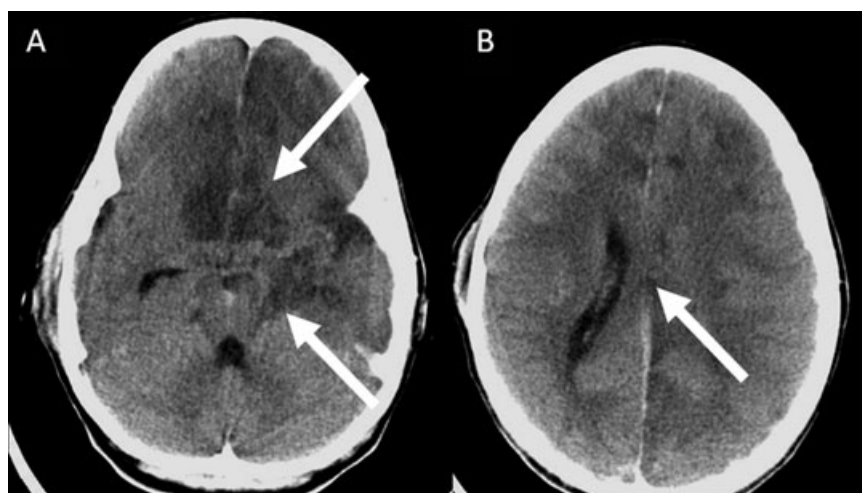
Axial CT images (A, B) show the complications of subfalcine and descending transtentorial herniation because of a left sided convexity SDH. The midline is pushed to the right, the left ventricle is compressed, the right ventricle obstructed. Downward herniation with compression of branches of the anterior circulation and anterior choroid artery have resulted in focal ischemic infarction of the hypothalamus bilaterally, both frontal lobes (left > right) and of the left cingulate gyrus and hippocampus. A focal hypodense cortical contusion is seen in the left temporal lobe.
